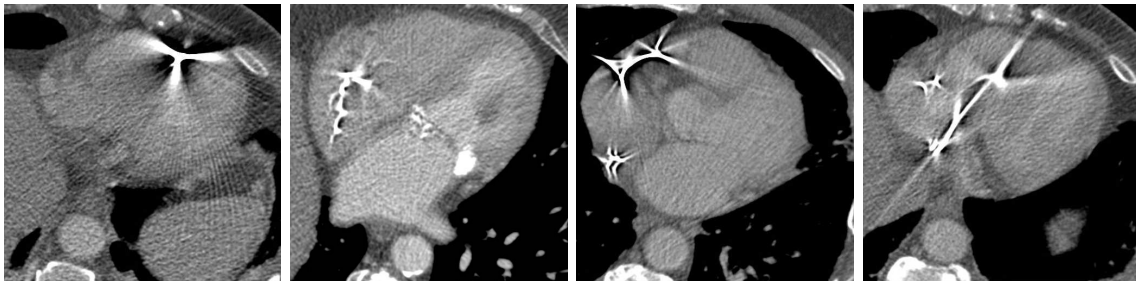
Pacemakers may lead to heavy streak-shaped artifacts in cardiac CT images. Especially in ungated CT data, motion aggravates artifacts caused by electrodes and leads.
